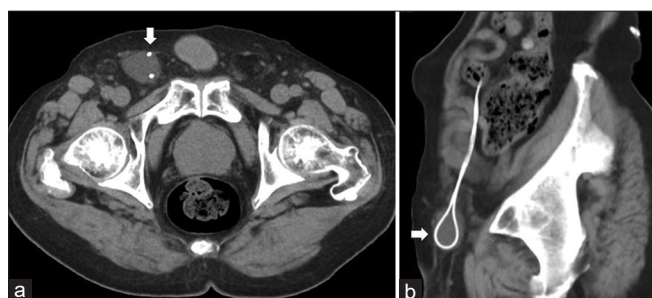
Abdominal computed tomography showing the presence of a lumboperitoneal shunt distal catheter in the right inguinal hernia sac with ascites (white arrow). (a: Axial slice, b: Sagittal slice).
